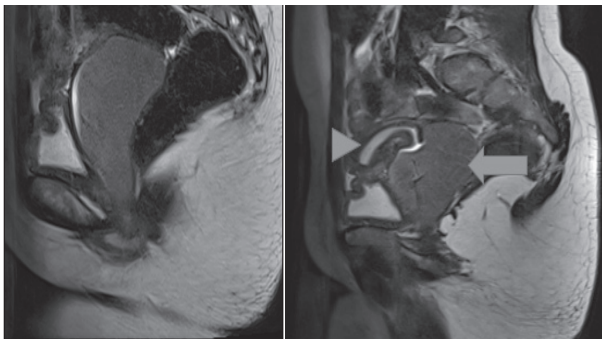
T2 Weighted MRI, Sagittal View Showing the Cervix Protruding into the Endo-vaginal Blood Collection (opened arrow). The Endometrium (arrowhead)
